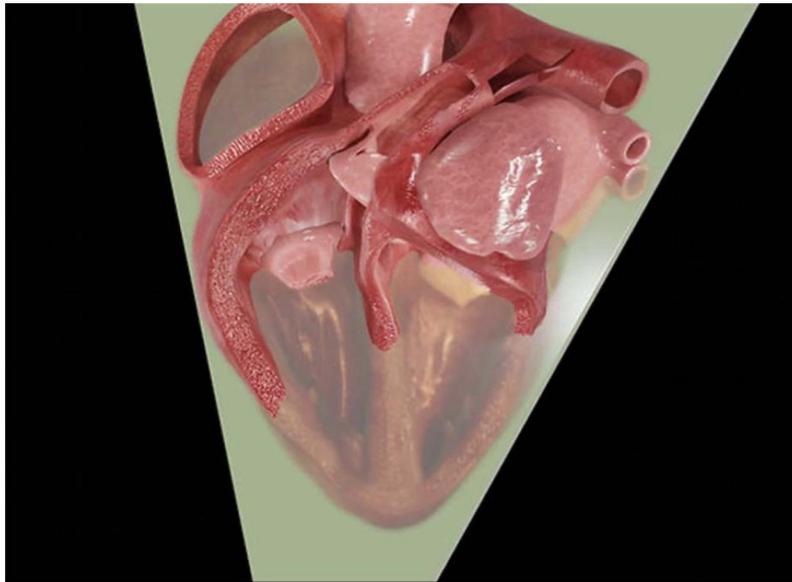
Three-dimensional (3D) animation of heart showing ultrasound (US) plane of apical 4-chamber (A4C)⁵.
